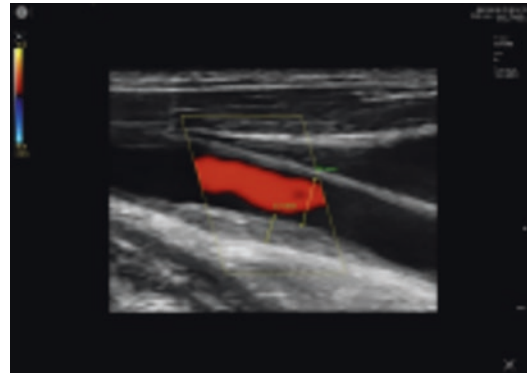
This is a CIMT ultrasound image of cardiovascular disease showing intimal thickening of 13 mm maximal depth indicating increased cardiovascular health risk. The color Doppler flow (red) is noted
